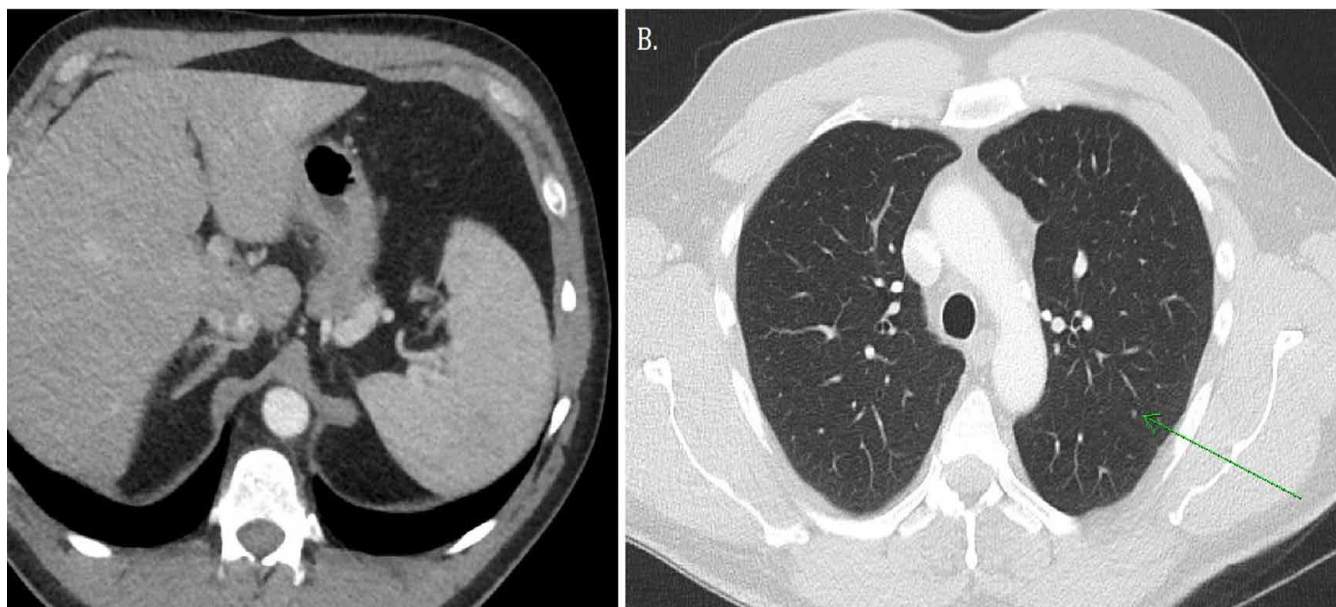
(A) CT chest demonstrating an expansile destructive right rib lesion measuring 5.8 x 4.1 x 6.5 cm and (B) non-specific 3 mm pulmonary nodule.
